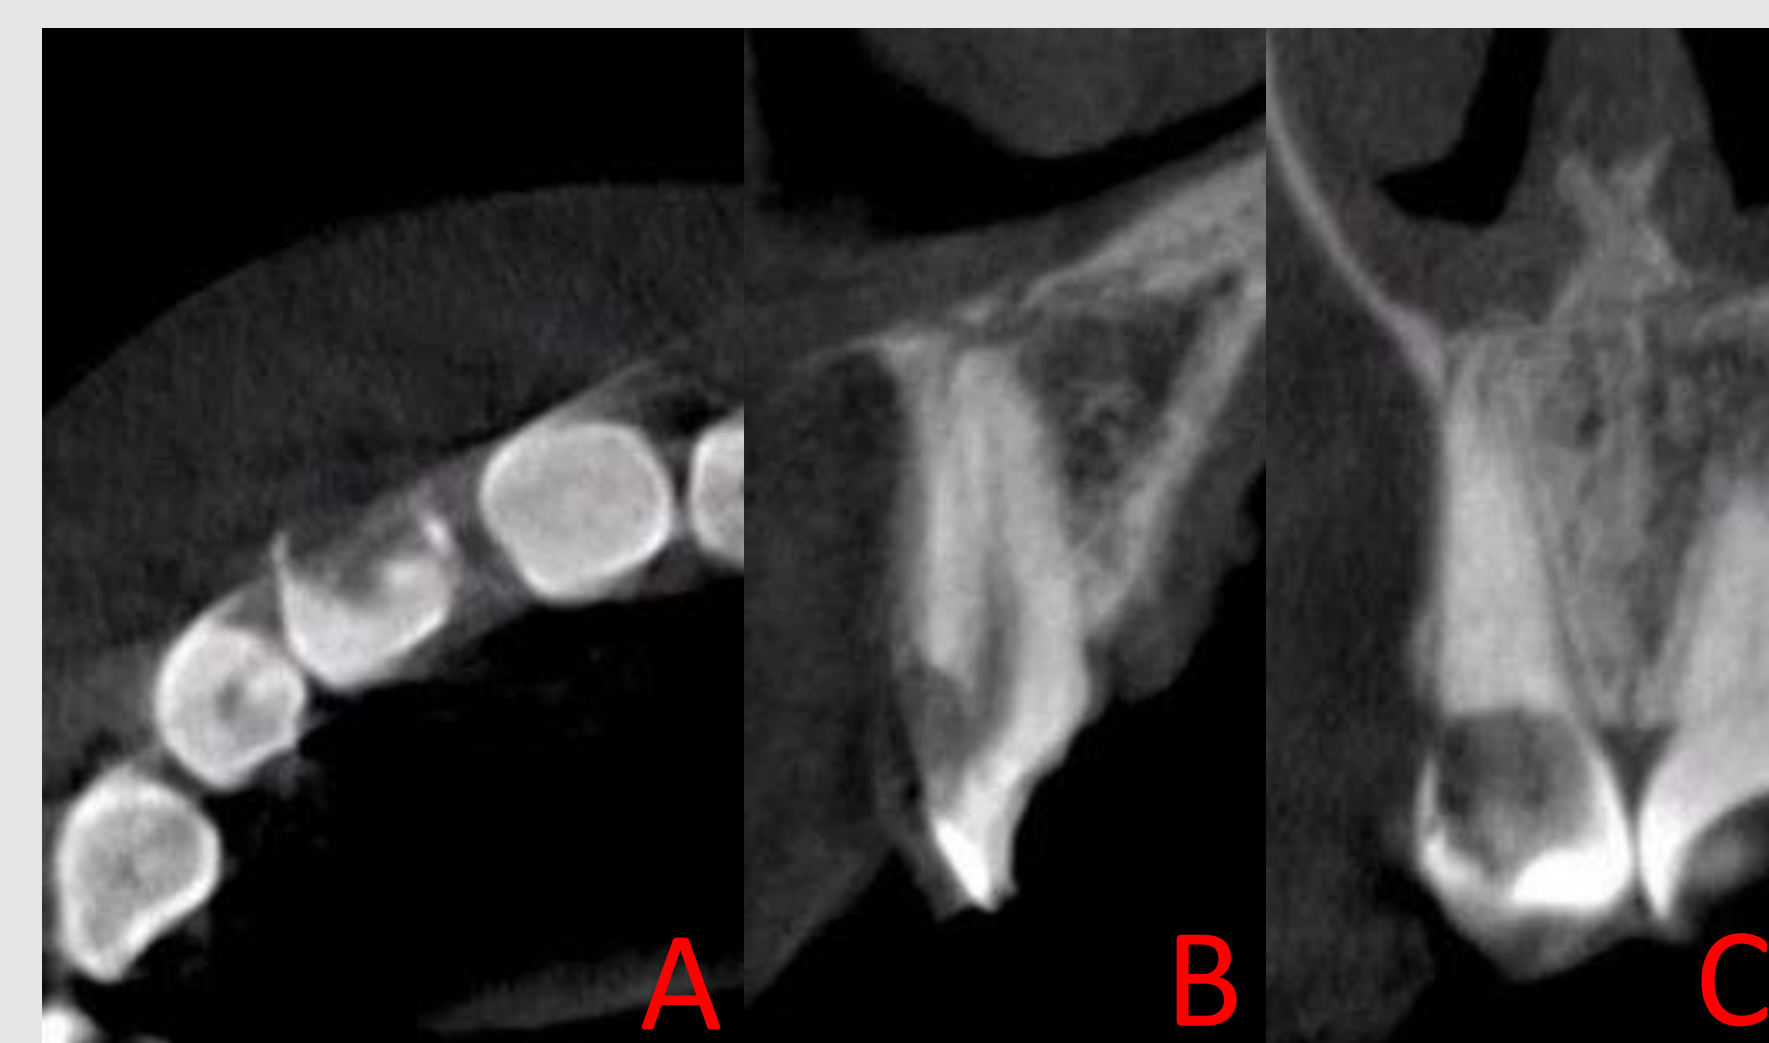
Preoperative CBCT: (A) axial, (B) sagittal and (C) coronal view
